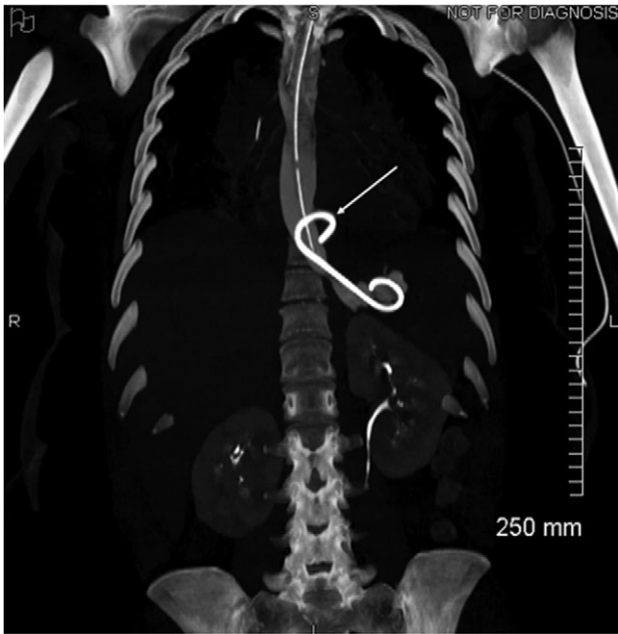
Coronal view of opacification on CT showing the externalization of the drain in the pericardium (arrow).
